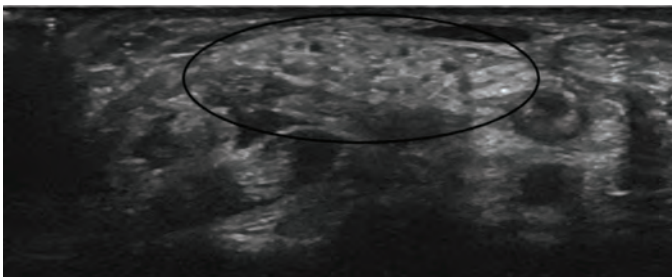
An 11-year-old boy with LFH of the median nerve. The extremely thick median nerve (circle) is seen in axial planes of sonography of the wrist
